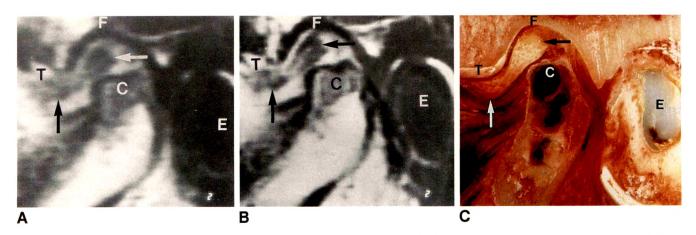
A and B, MR images obtained with 0.3-T scanner by using 2.5-min (A) and 11-min (B) scanning times show normal disk position. Anterior is to left. Quality of 11-min images was rated superior to that of 2.5-min images. Erosive change superiorly on condyle is best viewed in 11-min image.
